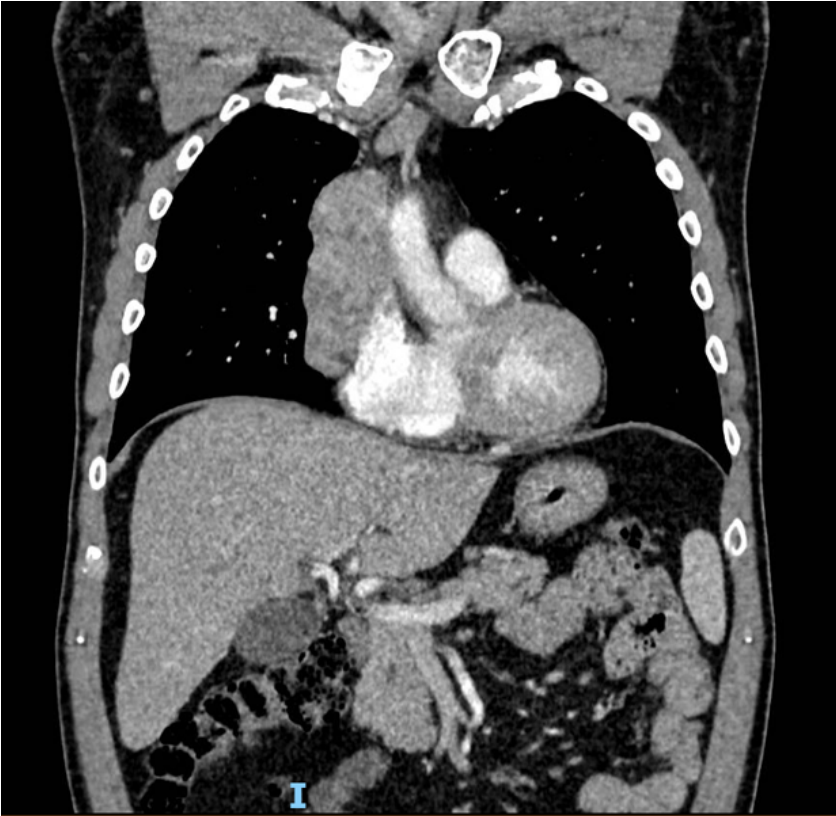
Computed tomography scan showing the mediastinal mass.
